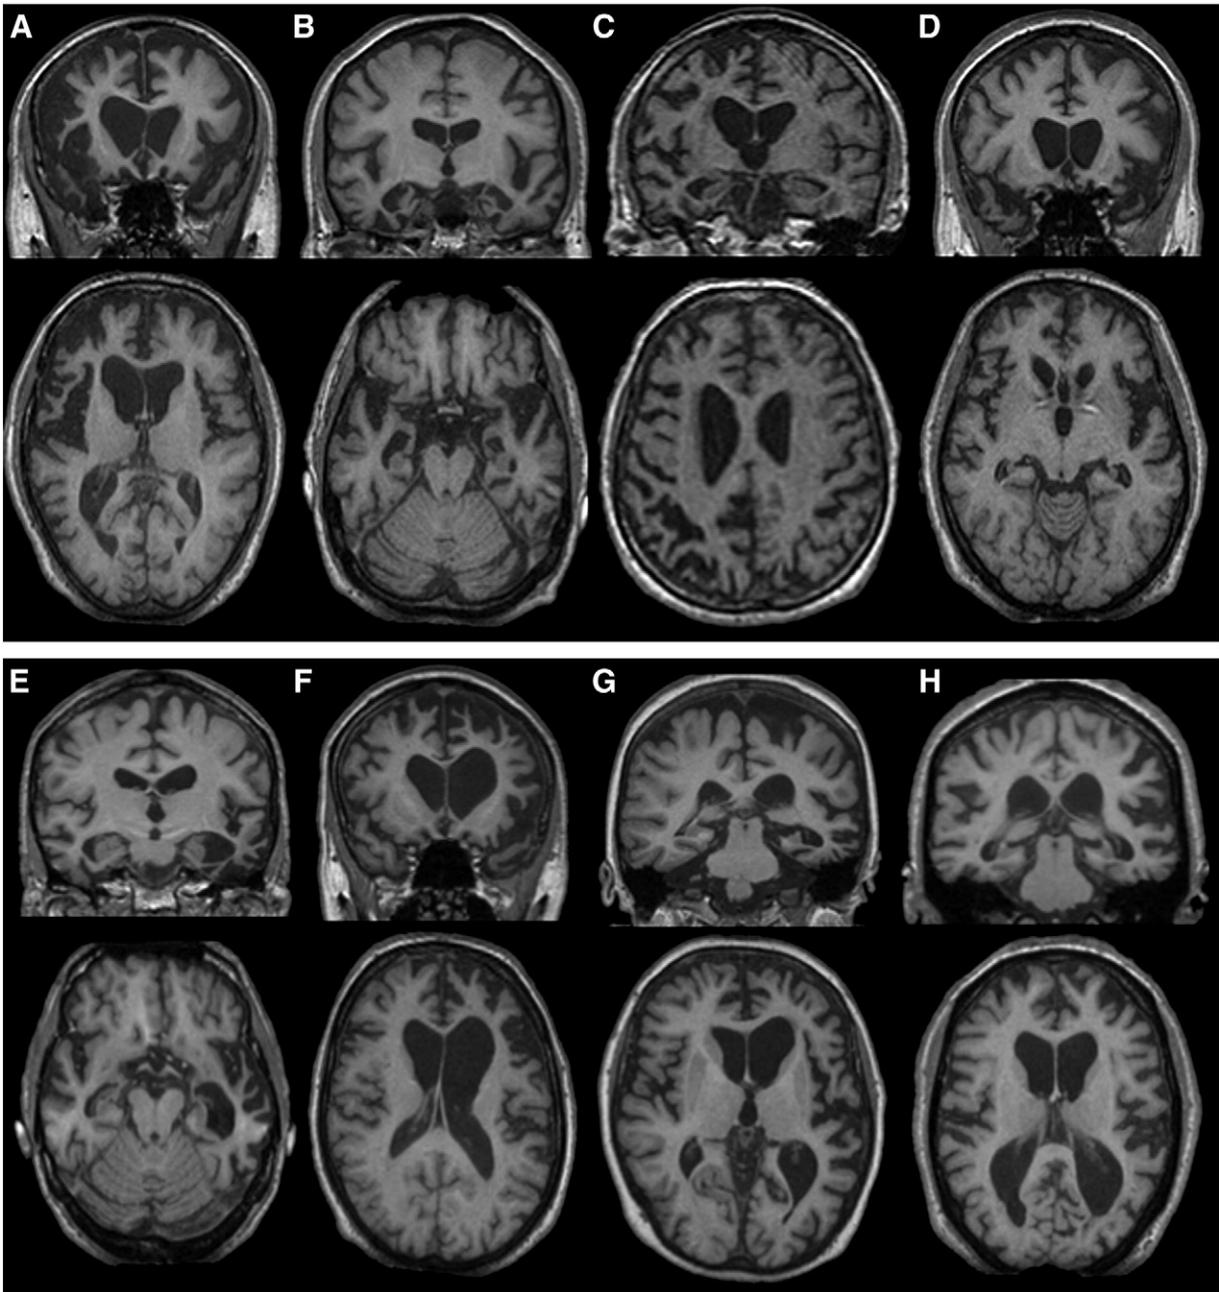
Examples of structural MR imaging in pathologically-confirmed frontotemporal dementia syndromes. Legend: Images each show coronal (top) and axial (bottom) sections for bvFTD (A FTLD-tau Pick's disease, B FTLD-tau *MAPT* mutation, C FTLD-TDP type A with *GRN* mutation, D FTLD-FUS aFTL_{DU}), SD (E FTLD-TDP type C), PNFA (F FTLD-tau Pick's disease, G *GRN* mutation) and LPA (H Alzheimer's disease).
